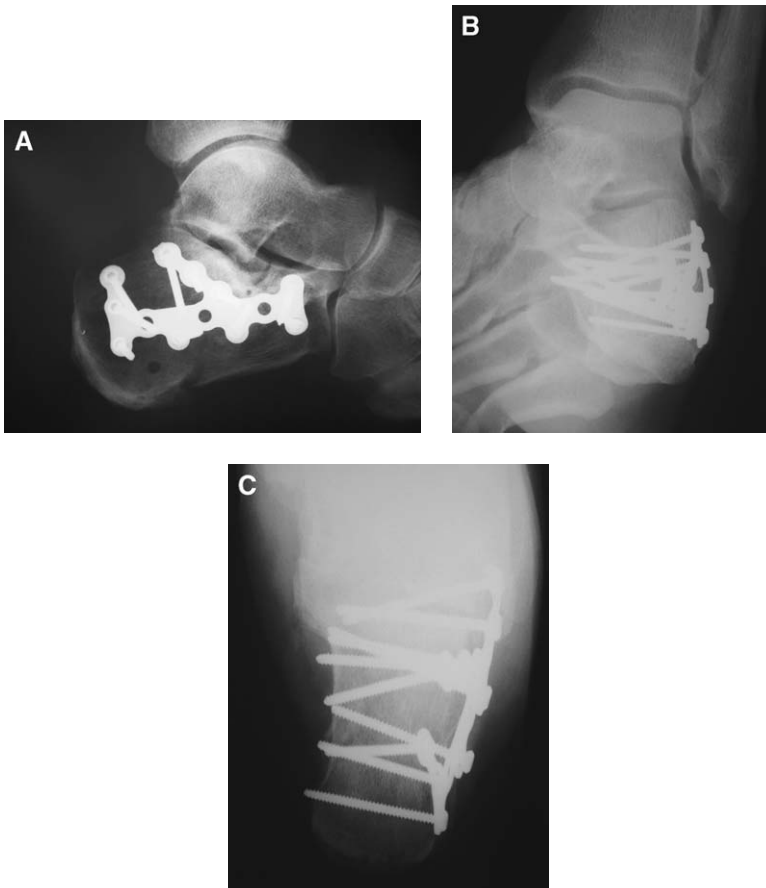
(A) A lateral radiograph of a calcaneus that was reduced in a standard open fashion using the extended lateral approach. (B) A Brodén view of the posterior facet to show congruency. This view also can be obtained intraoperatively. (C) A Harris axial heel view showing adequate placement of hardware.
